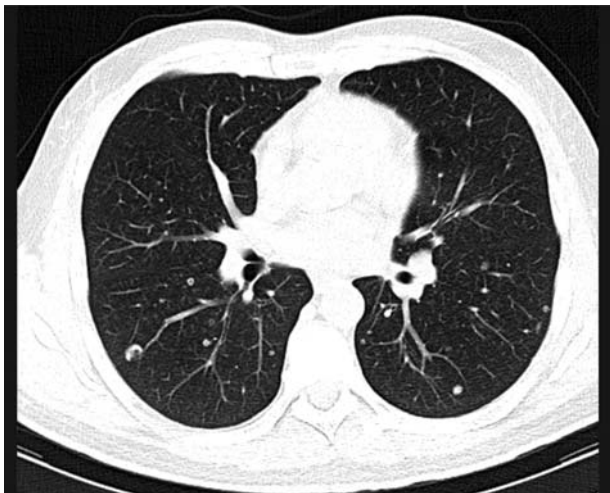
Chest CT scan with multiple metastases
